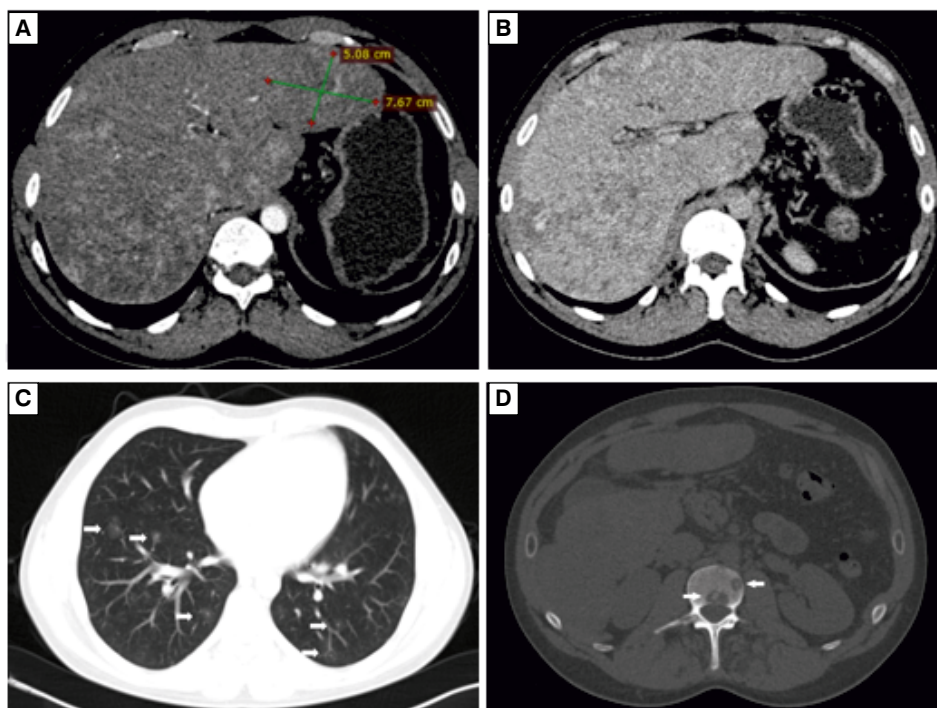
A. CT image of a lesion in the left liver lobe marked and measured, arterial phase; B. CT image of diffuse liver infiltration with numerous small nodules, venous phase; C. CT image of metastases to the lungs; D. CT image of metastases to the vertebrae
